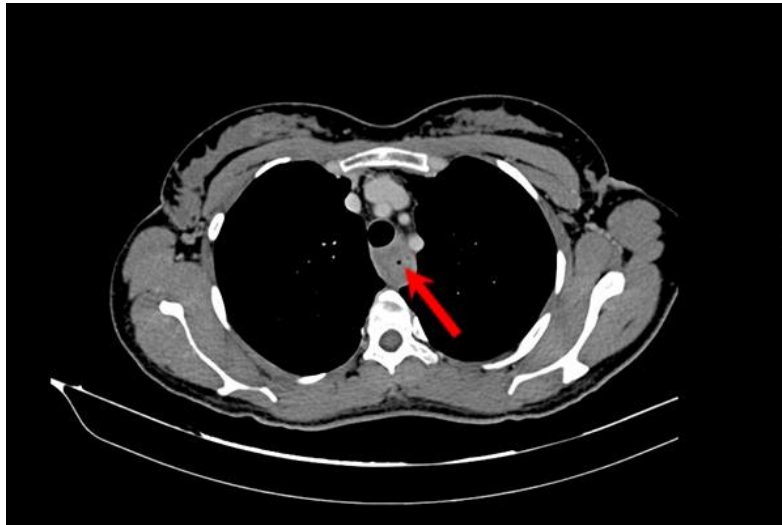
Computed tomography of the chest – Circumferential constriction of the esophageal lumen
